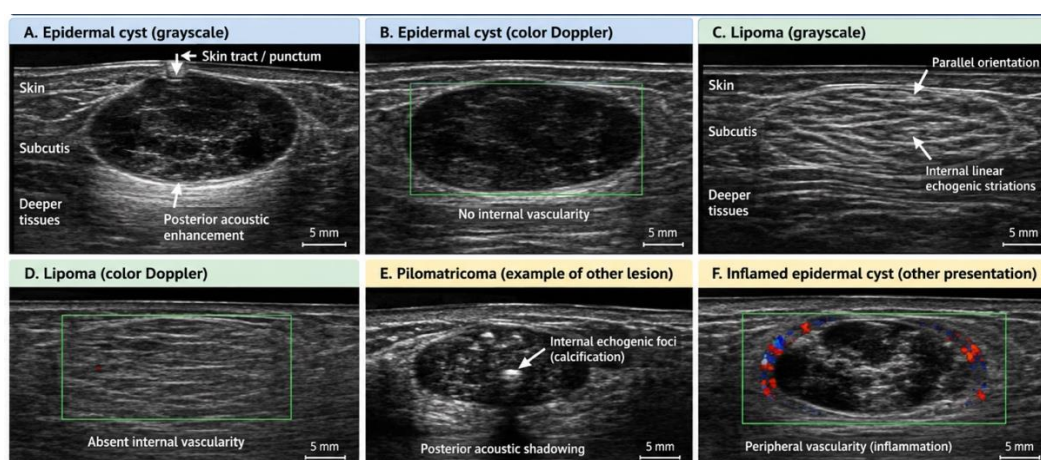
Representative high-frequency ultrasonographic features of epidermal cysts, lipomas, and other superficial subcutaneous lesions.
